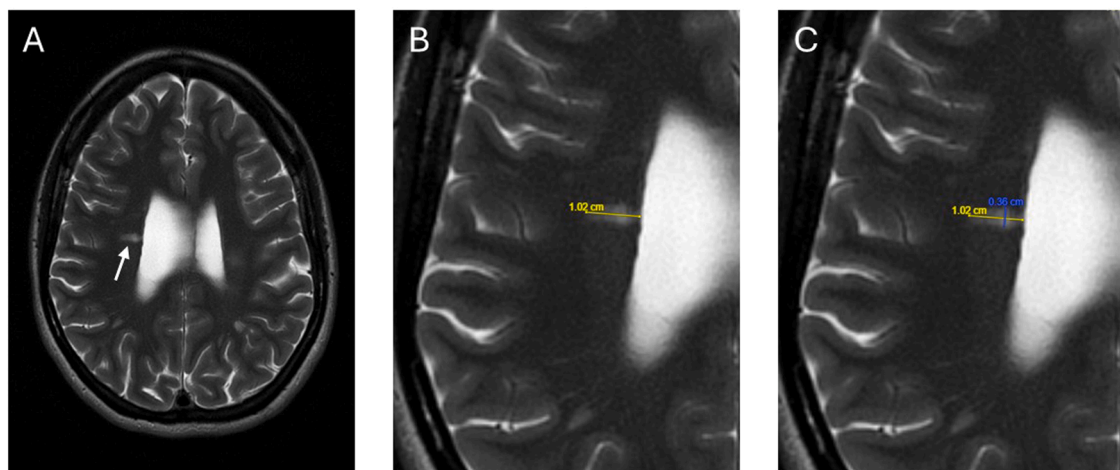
Manual measurement of the volume of brain white matter lesions on axial T2-weighted magnetic resonance images, using the following formulae: $V = \frac{4}{3}\pi abc$, where $a = \frac{1}{2}$ long-axis diameter, $b = \frac{1}{2}$ diameter of the axis perpendicular to the long-axis, and $c = \frac{1}{2}$ the number of slices in which the lesion is visible multiplied by the slice thickness. (A) A periventricular white matter lesion on an axial T2-weighted brain image (white arrow), (B) diameter of its long-axis (yellow line; 1.02 cm), and (C) diameter of the axis perpendicular to the long-axis (blue line; 0.36 cm).
